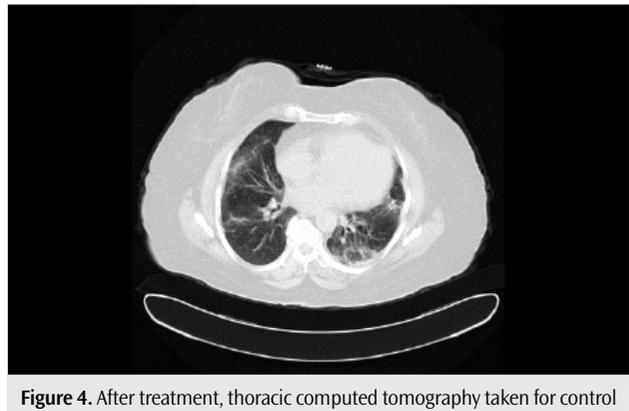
After treatment, thoracic computed tomography taken for control
